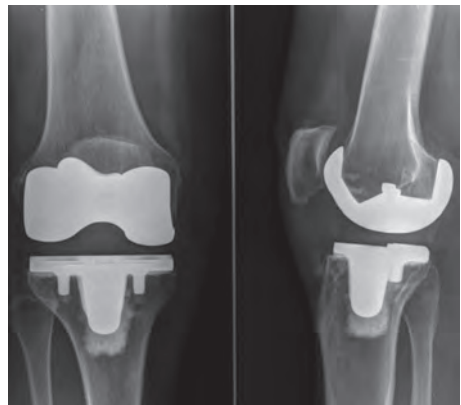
One year postoperative radiograph of a right customized TKR in a young and active female patient.
